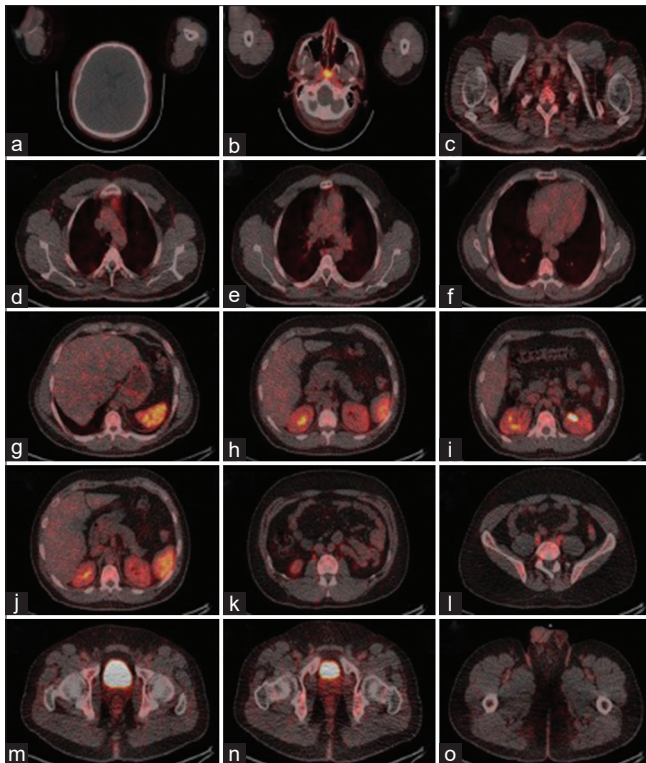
^{68}Ga -Pentixafor positron emission tomography/computed tomography transaxial images showing accumulation of Ga-68 Pentixafor in normal organs (a) brain (b) nasopharynx (c) thyroid (d) aortic arch (e) lungs (f) myocardium (g) stomach, liver and spleen (h) pancreas (i) adrenals (j) kidneys (k) L1 vertebra (l) cecum (m) urinary bladder (n) gluteal muscle (o) femur. The SUV_{mean} and SUV_{max} values of the tracer on the transaxial images over these regions were computed and reflected the normal physiological uptake pattern of the tracer
